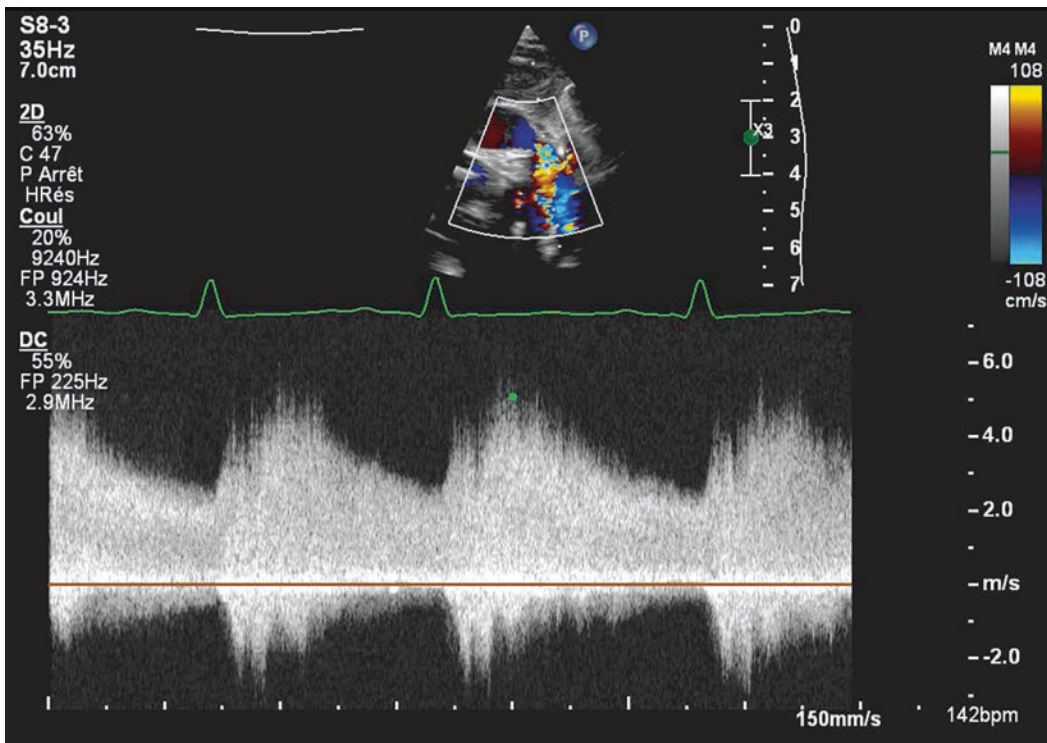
Doppler high velocity left to right shunt (5 m/s) through the PDA, allowing to estimate a systolic pressure gradient of 100 mmHg (Bernoulli = $4 \times V^2$) between aorta and PA (restrictive PDA)
